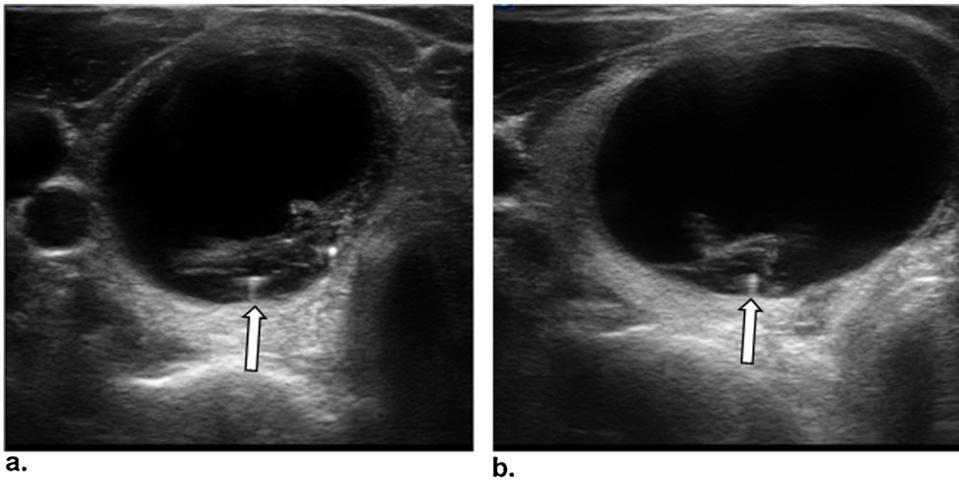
A 38-year-old man with a clinically suspected thyroid nodule. (a) Transverse and (b) longitudinal gray-scale ultrasound show a nodule at right thyroid lobe (arrows). The nodule is well-defined, predominantly cystic, isoechoic, and shows comet tail artifact. The nodule was categorized as TR2. Cytology showed a colloid/hemorrhagic cyst.
